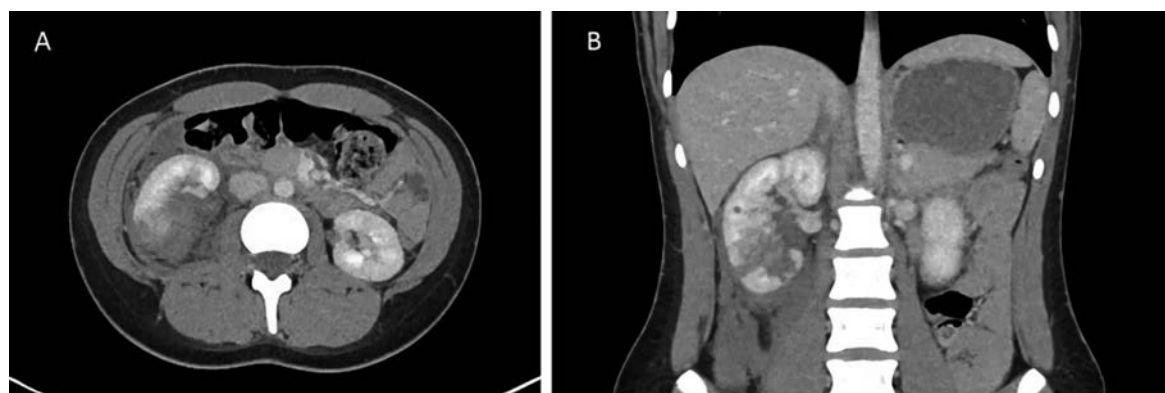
Computed tomography (CT) scan of abdomen and pelvis showing a complex right lower pole renal laceration (AAST Grade III).
